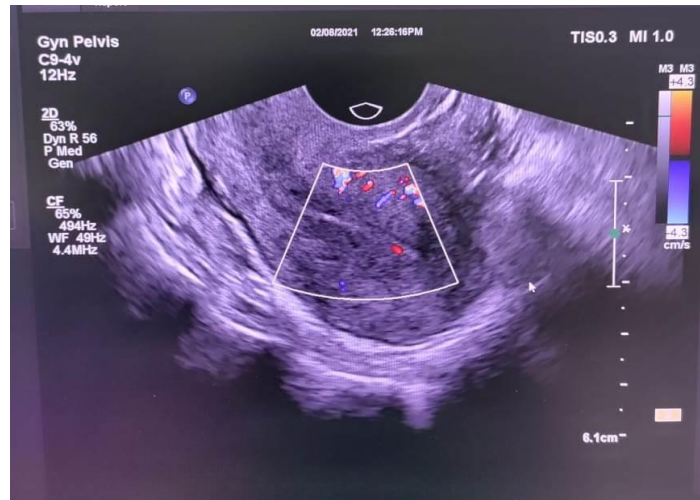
Ultrasonography findings of the endometrium.
